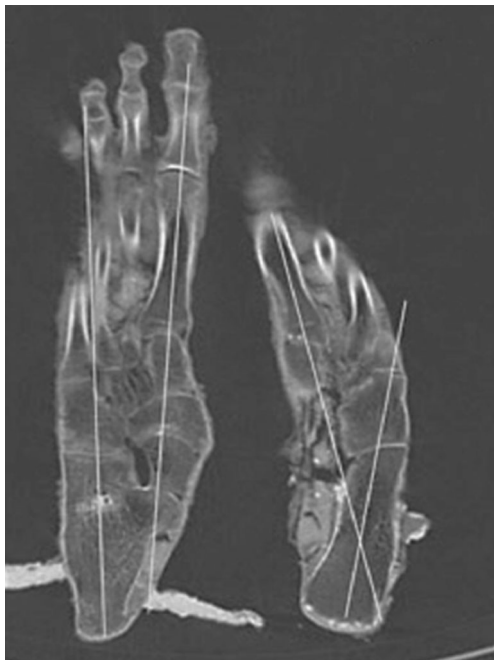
CT scan of Tut-Ankh-Amun's feet showing shorter left foot, the seat of varus deformity
